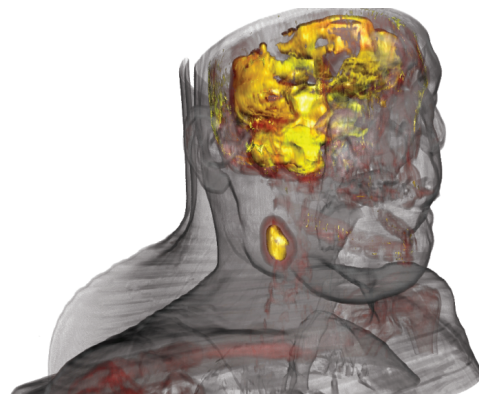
Multimodal visualization of a CT and PET scan. The more opaque regions symbolizes regions of high activity such as in the brain and in the tumor on the neck.
